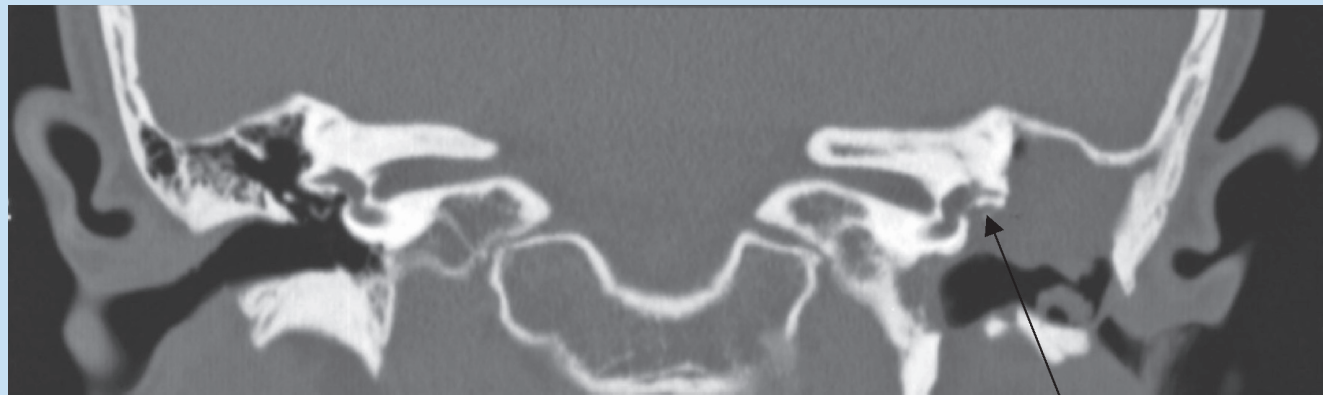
Coronal CT displaying erosions adjacent to the vestibule (arrow).
